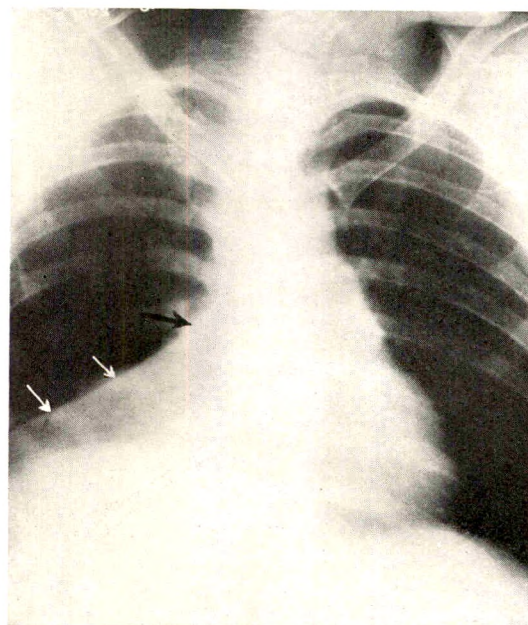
Roentgenogram of Case IV showing the characteristic triangular shadow on the right of the median shadow extending from the hilus to the diaphragm. Arrows indicate the lateral border of the encapsulation.
